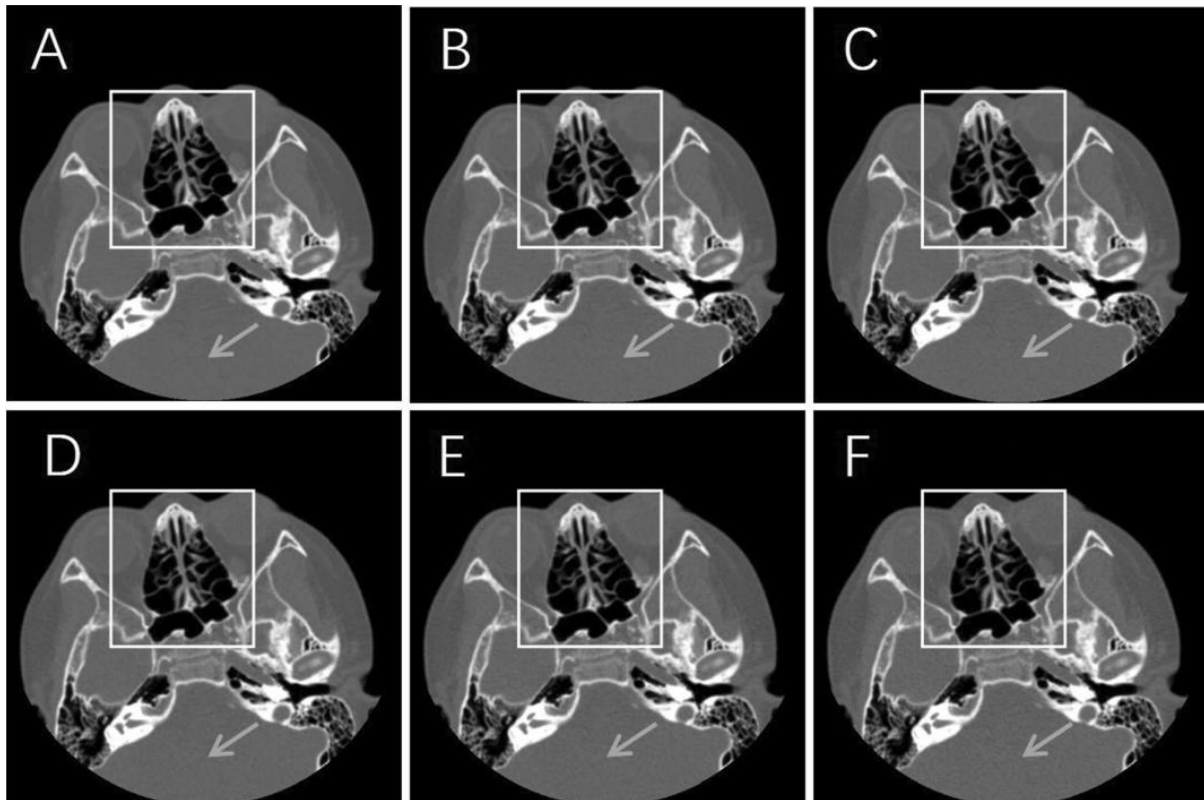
Axial CT bone window images from different reconstruction algorithms. A DLIR-high, B DLIR-medium, C DLIR-low, D AsirV-50%, E AsirV-30%
